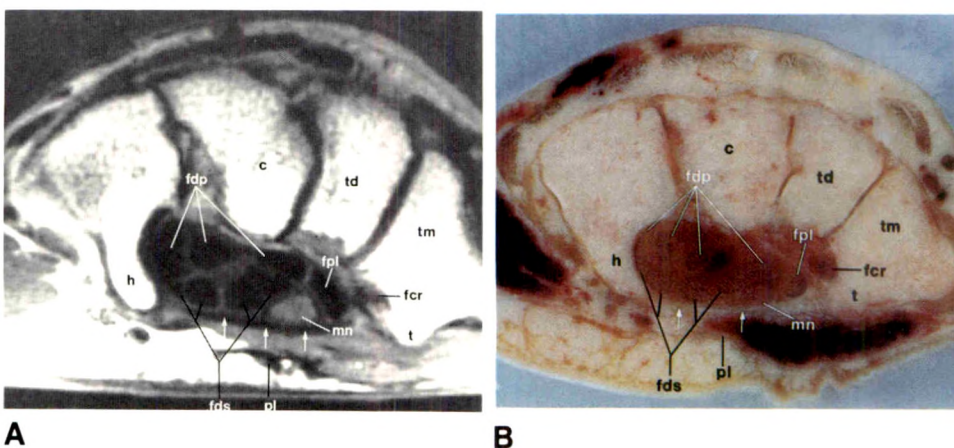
Axial MR image (TR 600, TE 25) (A) and anatomic section (B) at level of hook of hamate. Right wrist viewed toward elbow with palm down. Flexor retinaculum (arrows). (See key for abbreviations.)
